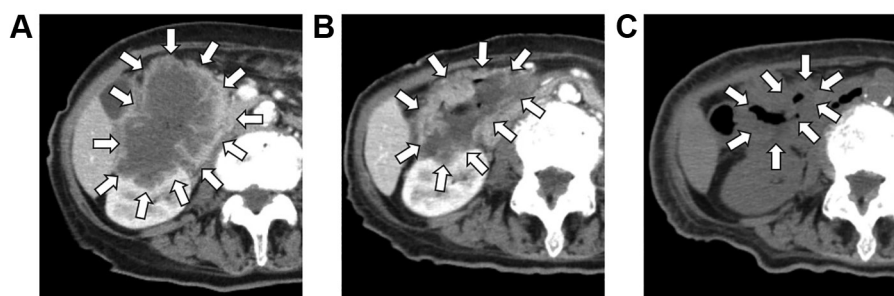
Time course of abdominal computed tomography images. Abdominal computed tomography showing a large tumor (white arrows) located in the right upper abdomen before treatment (A). The size of the tumor decreased after two courses of combined CBDCA and nab-PTX therapy (B), and 10 days after the administration of larotrectinib (C). CBDCA: Carboplatin; nab-PTX: nab-paclitaxel.
